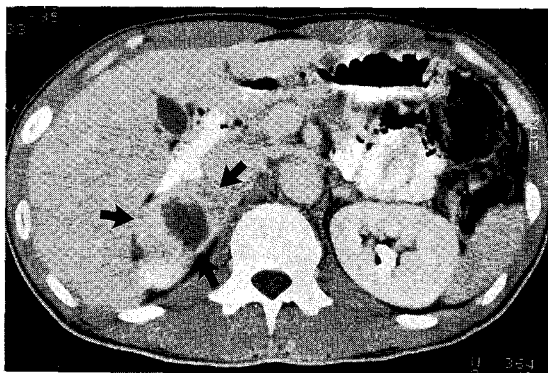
Abdominal CT with contrast enhancement demonstrates a solid enhanced mass in the right adrenal gland with a central area of low attenuation (arrows).
